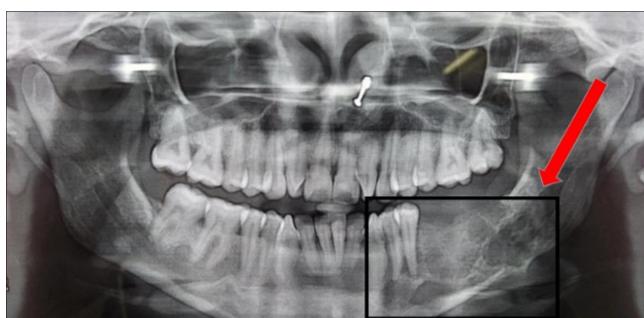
Orthopantomogram showing a multi-locular radiolucency
